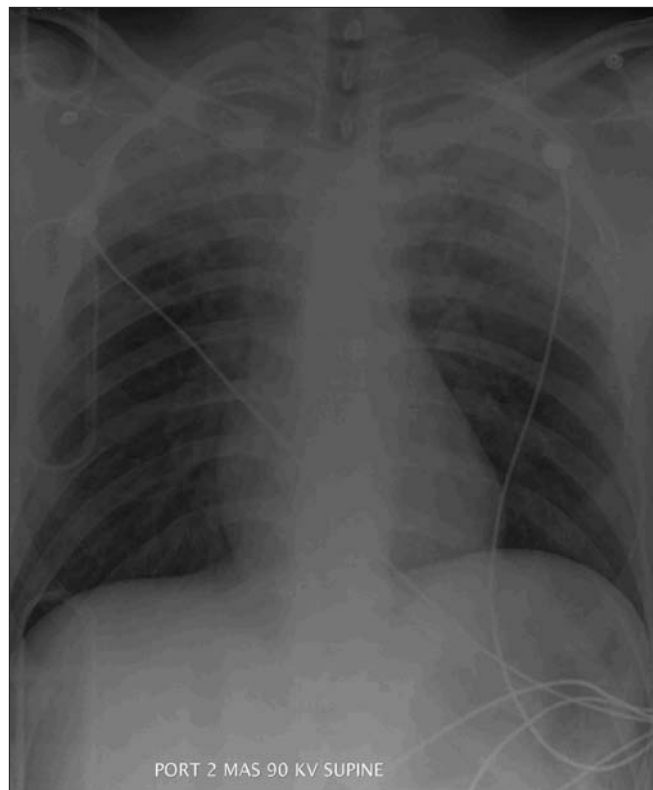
Chest radiograph showing significant bilateral, symmetrical and apical airspace disease.
